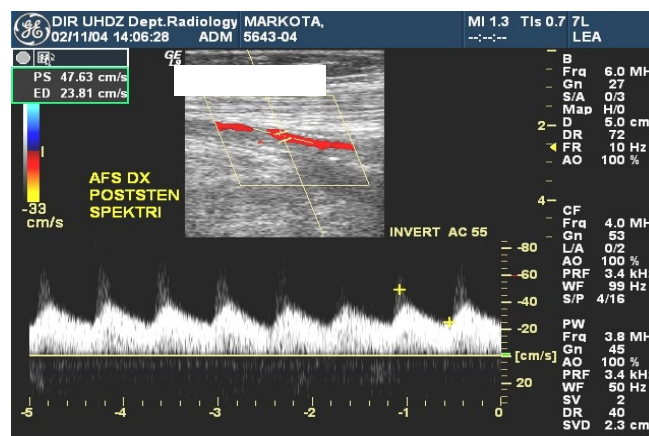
Postocclusive biphasic spectrum with low velocities distally from the occlusion in femoral artery. The display with color duplex Doppler, with electronic steering of the beam. Doppler sample volume is positioned in the center of the artery. Graphic display demonstrates changes of velocities in systole and diastole.
